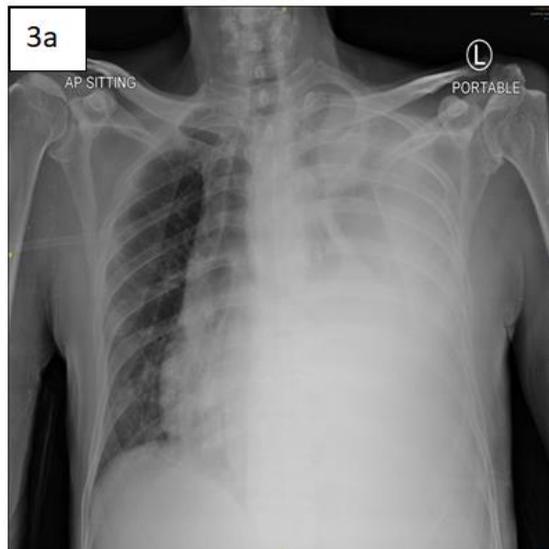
AP chest x-ray showing left sided white out opacification
